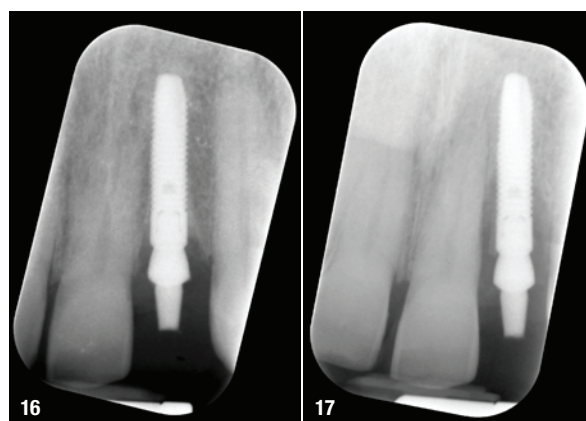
Baseline radiograph of the implant mapped in Figure 15, showing good marginal bone levels. – Fig. 17: Radiograph of the implant after three months of osseointegration, showing significant cratering of the crestal bone.
